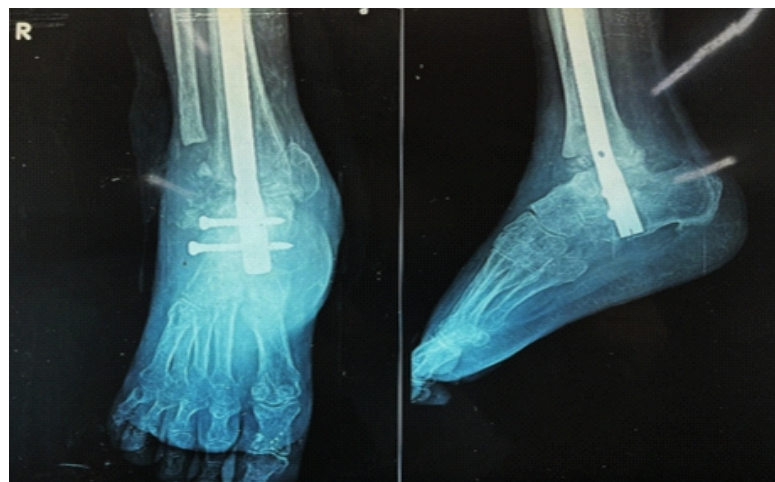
Anteroposterior and lateral radiographs of the right ankle demonstrating failed tibiotalocalcaneal arthrodesis with an intramedullary hindfoot nail in situ and absence of fusion at the ankle and subtalar joints.
